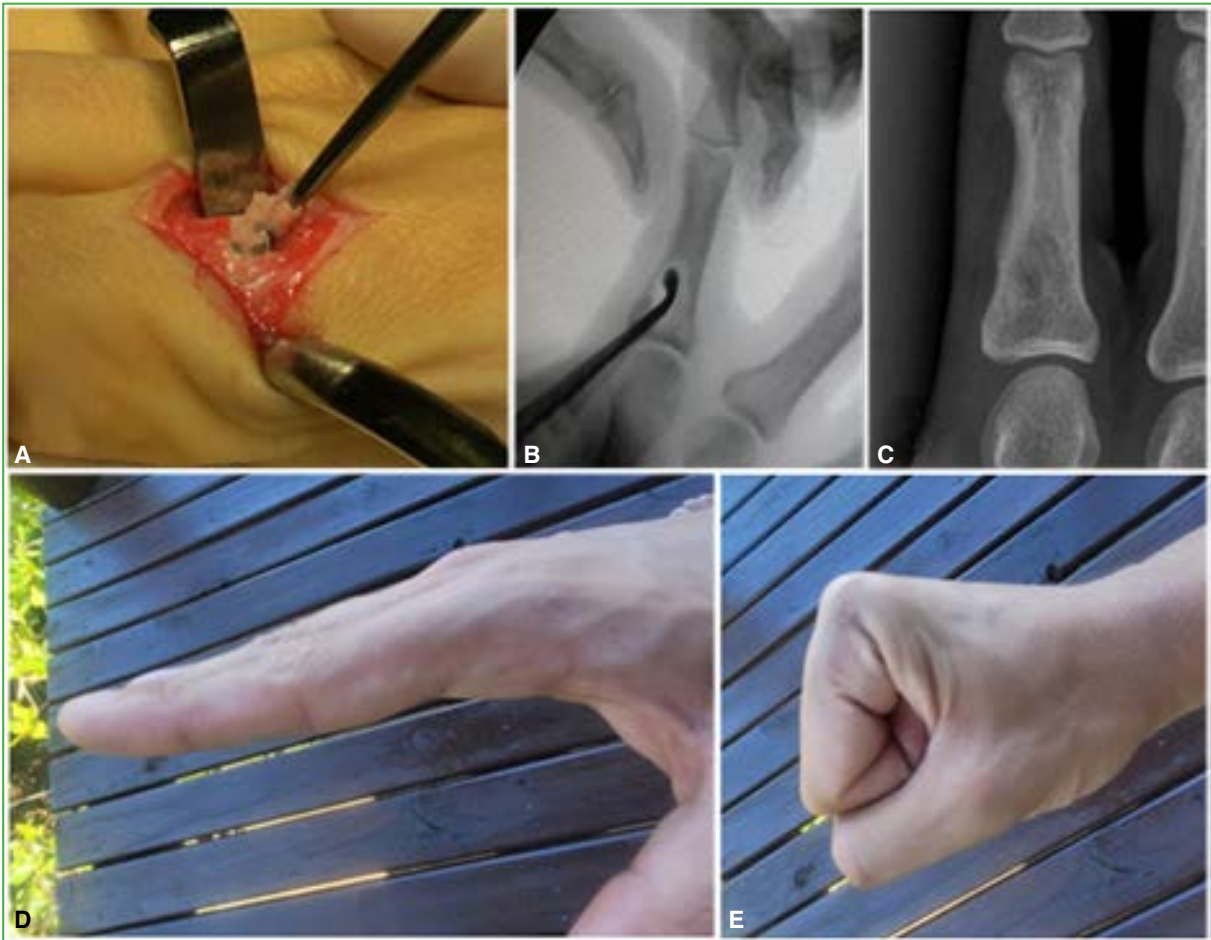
Case 4. A. Intraoperative clinical image showing the tumor. B. Intraoperative anteroposterior radiograph of the index finger showing intralesional curettage. C. Postoperative anteroposterior radiograph of the index finger showing bone healing. D and E. Final clinical outcome.
